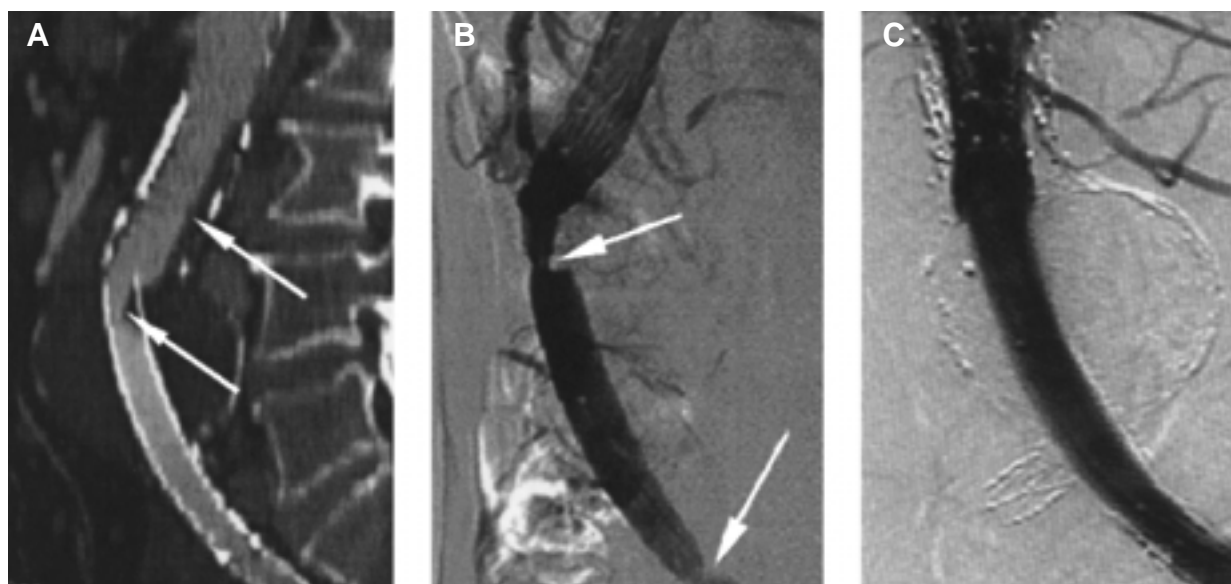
A, Multiplanar reconstruction of spiral computed tomographic scan that shows thrombus lining the stent graft (arrows). B, Angiogram that shows two areas of stenosis (arrows). C, Angiogram after implantation of additional Wallstent and balloon dilatation.
